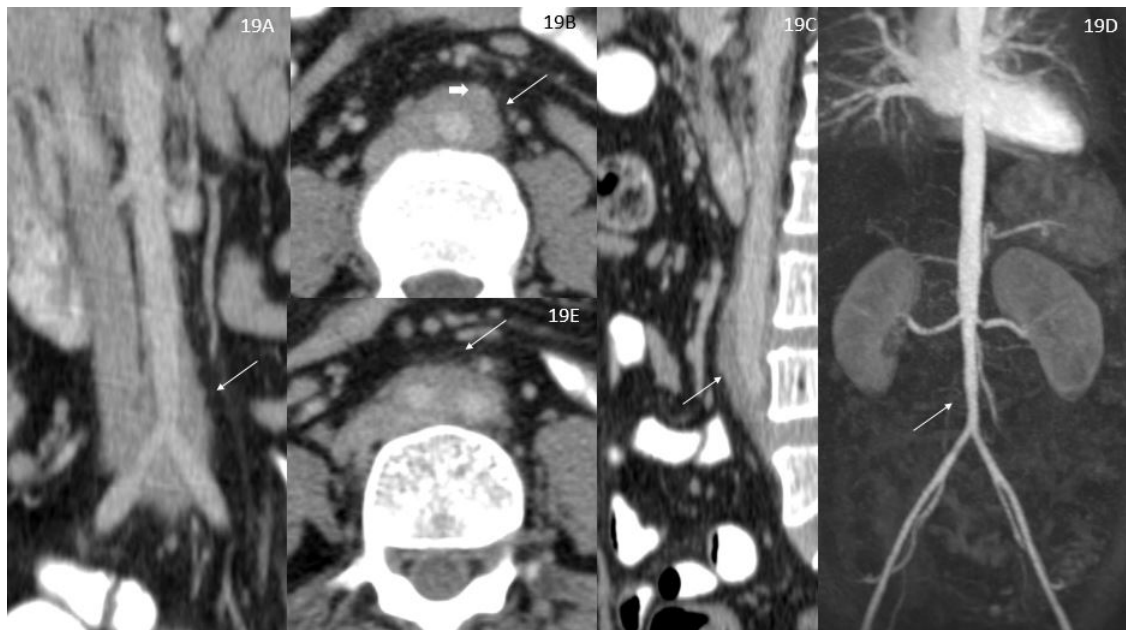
Case 5. A-C, E) Computed tomography image showing soft tissue thickening (indicated by white arrow) along abdominal aorta. D) Coronal MRI angiography revealed mild narrowing of infrarenal abdominal aorta
